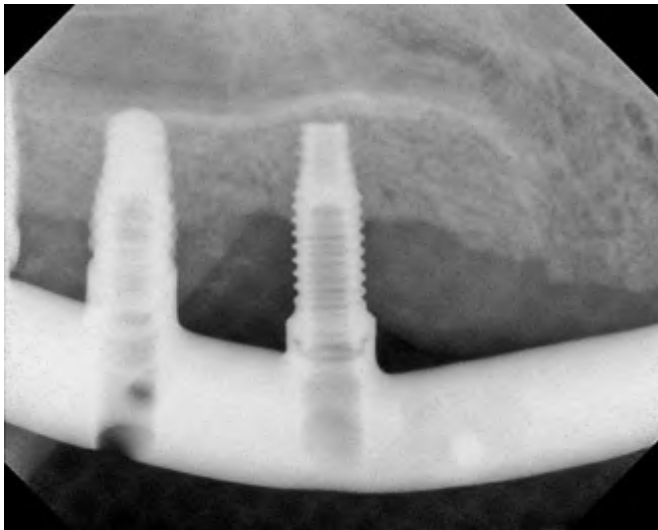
Another radiographic image that also demonstrated a passive fit of the maxillary framework to the maxillary implants. The abutment screw was in place in an implant not in the image (distal left implant). The framework was noted to fit without a radiolucency visible between the framework and the implant restorative platform of the two right implants in the image.
